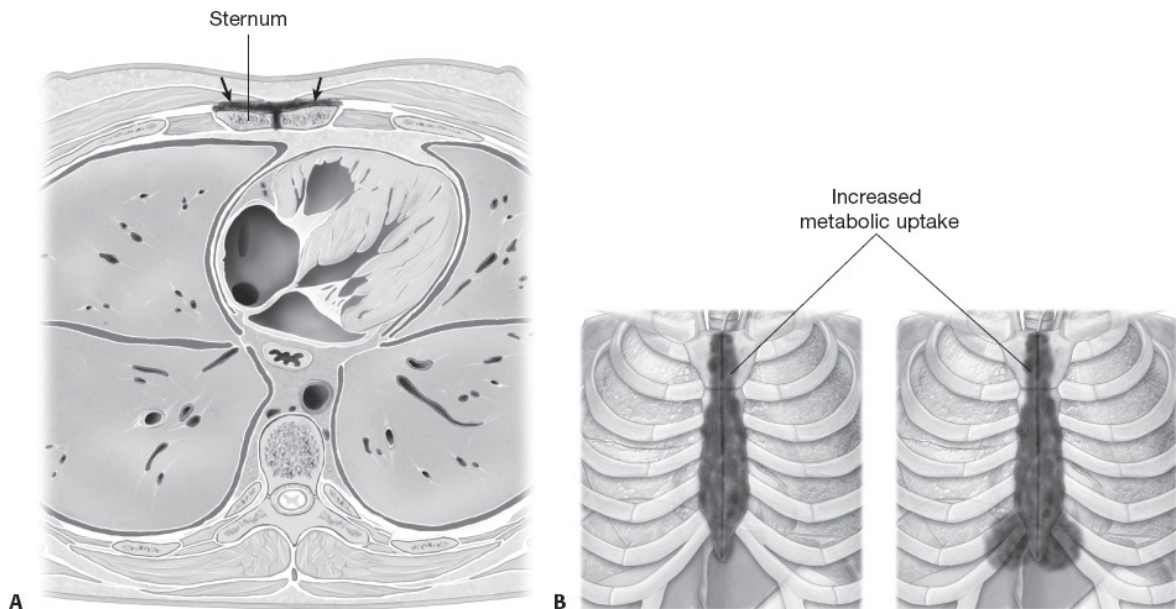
• A. Axial CT demonstrating fluid collection, as indicated by the *arrows*, resulting in the separation of the sternum into two distinct halves. B. ^{99m}Tc-leukocyte scan taken at 4 hours (*left*) and 20 hours (*right*) after leukocyte radiolabeling. Diffuse uptake of the distal sternum is noted at 4 hours, with lateral extension at 20 hours. Surgical intervention confirmed infection in areas noted to have enhanced signaling. 20 hours after leukocyte radiolabeling. Diffuse uptake of the distal sternum is noted at 4 hours, with lateral extension at 20 hours. Surgical intervention confirmed infection in areas noted to have enhanced signaling.
